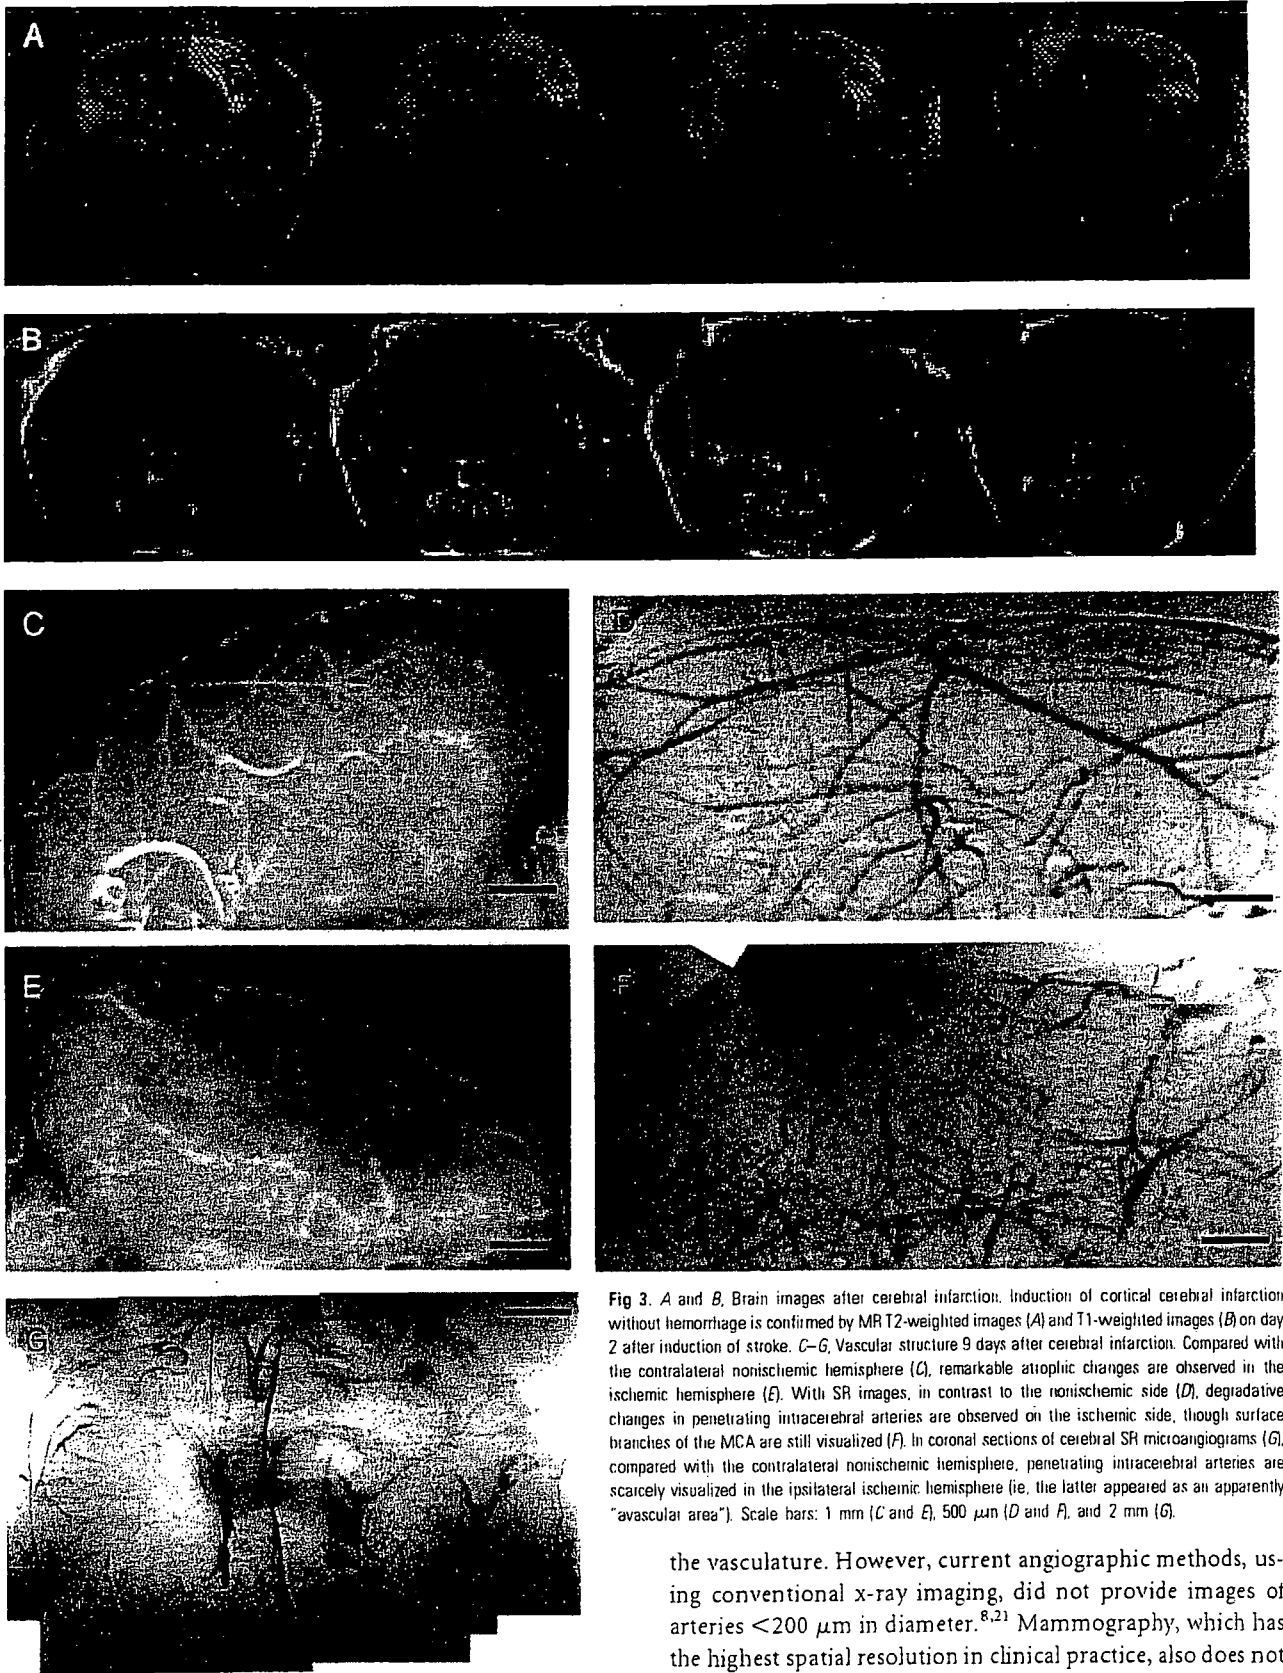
A and B*, Brain images after cerebral infarction. Induction of cortical cerebral infarction without hemorrhage is confirmed by MR T2-weighted images (*A*) and T1-weighted images (*B*) on day 2 after induction of stroke. *C–G*, Vascular structure 9 days after cerebral infarction. Compared with the contralateral nonischemic hemisphere (*C*), remarkable atrophic changes are observed in the ischemic hemisphere (*E*). With SR images, in contrast to the nonischemic side (*D*), degradative changes in penetrating intracerebral arteries are observed on the ischemic side, though surface branches of the MCA are still visualized (*F*). In coronal sections of cerebral SR microangiograms (*G*), compared with the contralateral nonischemic hemisphere, penetrating intracerebral arteries are scarcely visualized in the ipsilateral ischemic hemisphere (ie, the latter appeared as an apparently “avascular area”). Scale bars: 1 mm (*C* and *E*), 500 μm (*D* and *F*), and 2 mm (*G*).
